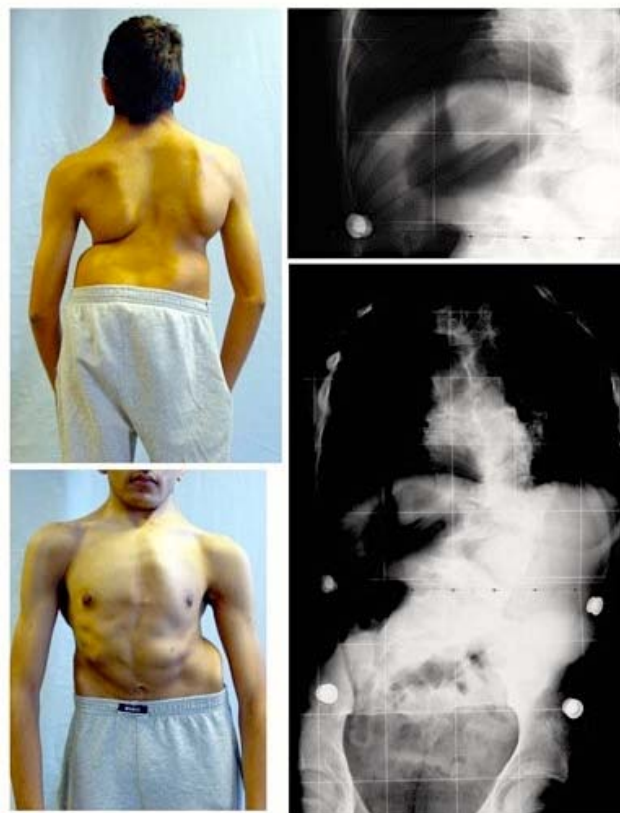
Patient with failure of segmentation (rib synostosis) with clinical and radiological improvement due to conservative treatment. This fifteen-year-old boy presented at age nine with congenital scoliosis with rib synostosis due to failure of segmentation, prior to the pubertal growth spurt. At the time of his last follow-up, his clinical appearance remained severe but with an improved cosmetic appearance. The radiographs demonstrate a scoliotic curve of 59 degrees with Risser sign 4. VC was 1.640 ml, 33% of the predicted value. This case was described in more detail in [5].
